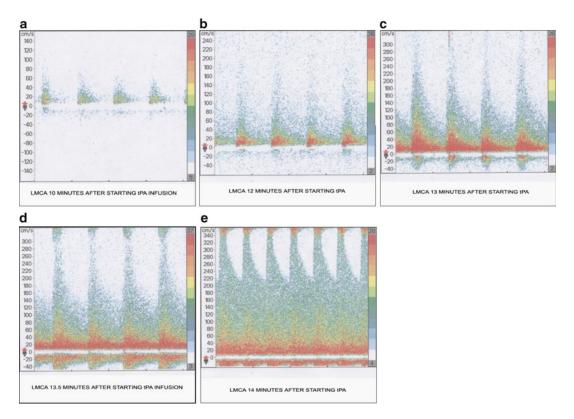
A 71-year-old male with acute onset left MCA (LMCA) syndrome at 2 h from symptoms onset. Given IV tPA at 2.5 h. Continuous monitoring of intracranial vessel status by transcranial Doppler (TCD) during IV
